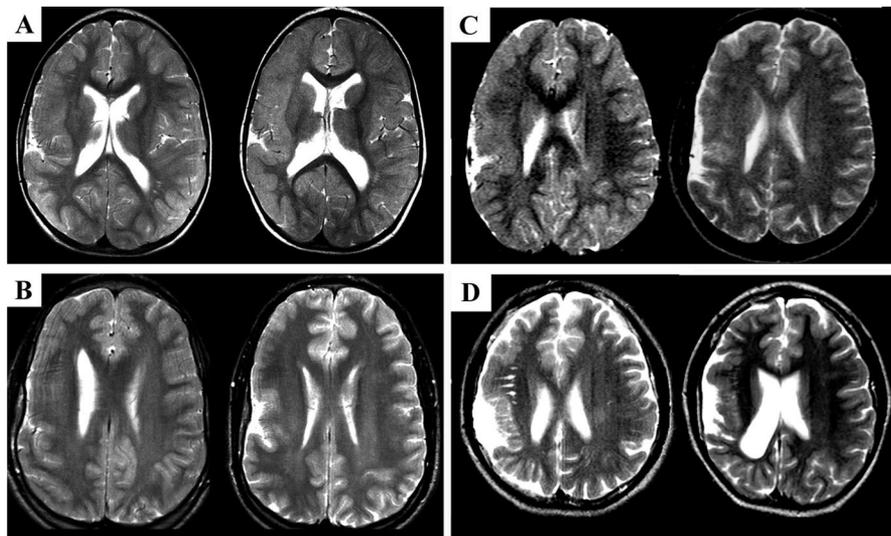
MRI appearance of unilateral right-sided polymicrogyria (PMG). Conventional T2-weighted spin-echo brain MRI in these families demonstrates that the PMG is quite stereotyped between the two members of each family but differs slightly between families. In all cases, the affected right hemisphere is smaller in size than the left. (A) MRI of the older brother (III:1; left) and younger brother (III:2; right) from Family 1 demonstrates unilateral right-sided PMG, characterized by an apparent increase in cortical thickness and an irregular, scalloped gray-white junction extending from near the frontal pole to the posterior end of the abnormally oriented, open sylvian fissure. (B) MRI of the younger brother (II:2;
